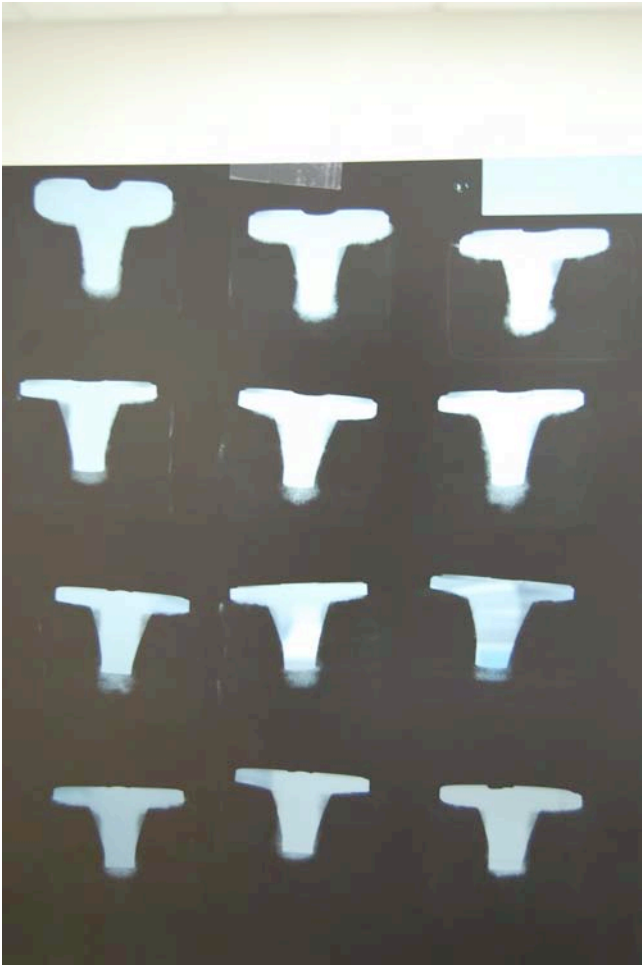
Radiographic analysis: Lateral view of the cement mantle
